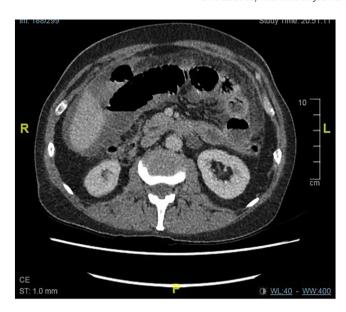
Axial view of CT abdomen and pelvis showing high density ascites and omental stranding.
